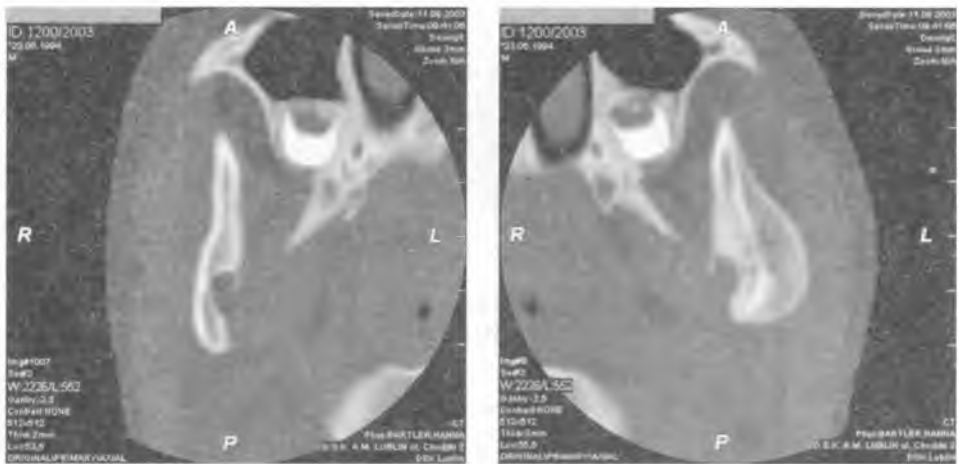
CT scan – another projection
